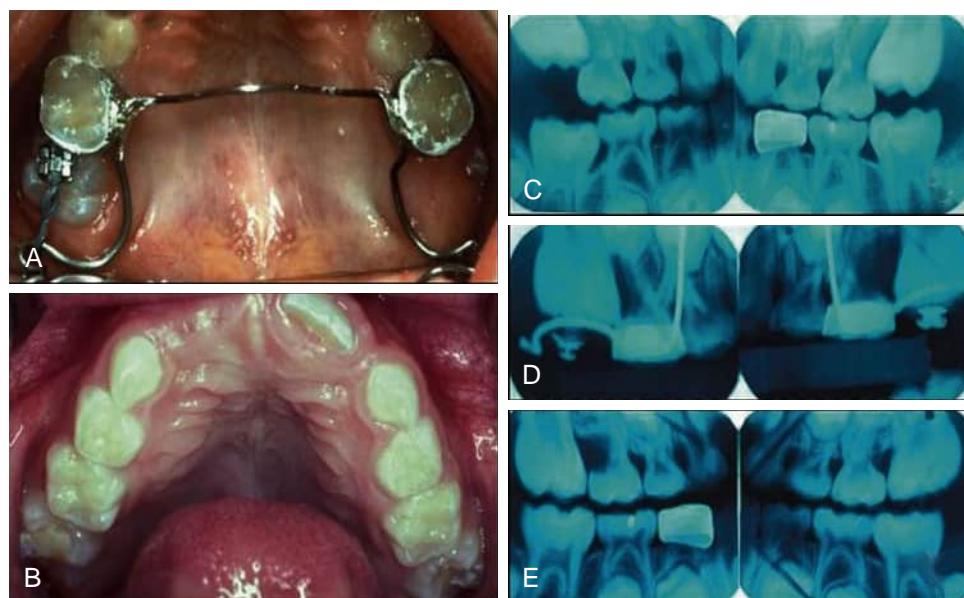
Fixed maxillary Halterman appliance. (A) Bands on second primary molars with distal engagement arms for engaging elastomeric chains to bonded attachments on bilateral ectopic first permanent molars. (B) The first permanent molar has erupted into a favorable position after 6 weeks' treatment time. Radiographs showing distal repositioning of the first permanent molar from (C) pretreatment, (D) at 2 weeks of treatment, (E) to 1 year posttreatment.
